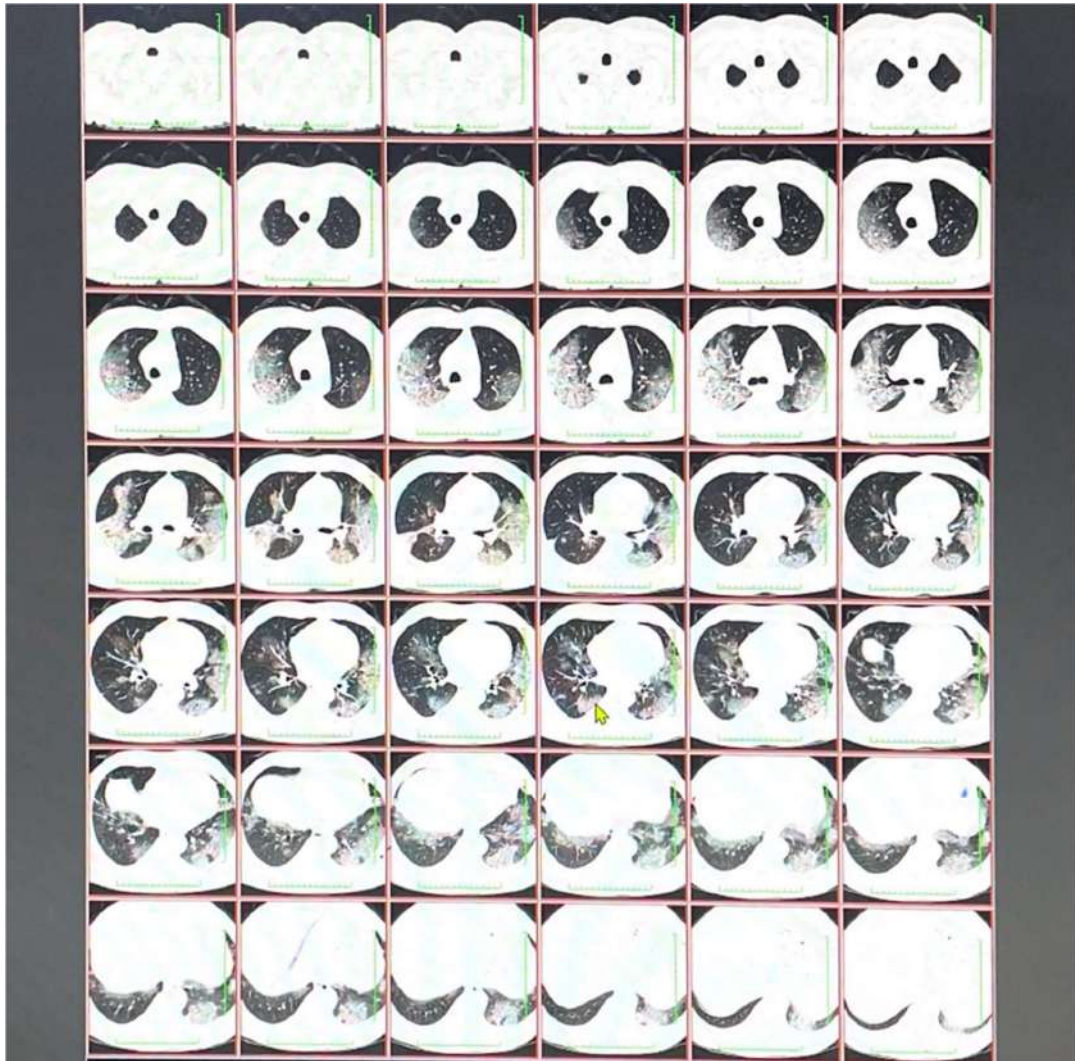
HRCT CHEST - Both lungs show diffuse ground glass opacities with smooth interlobular and interseptal reticular thickening noted with upper to lower lobe gradient and subpleural region. Mild bronchiectatic changes with peri bronchial wall thickening in both lungs
